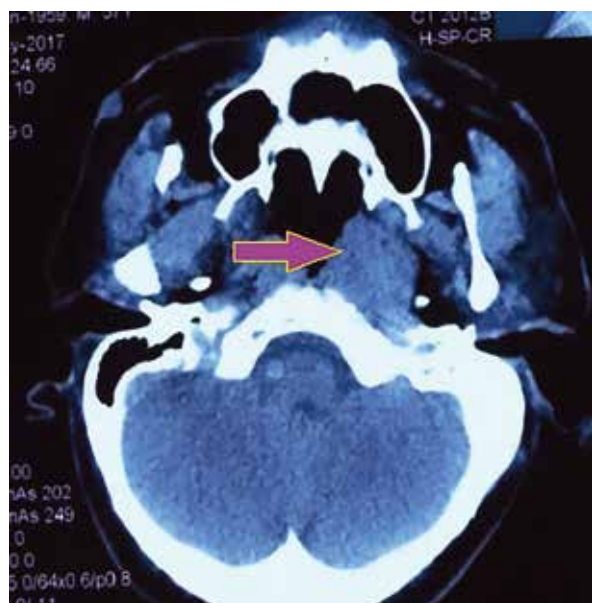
CT of the neck showing obliteration of the nasopharynx (arrow) by a mass arising from the fossa of Rosenmüller
